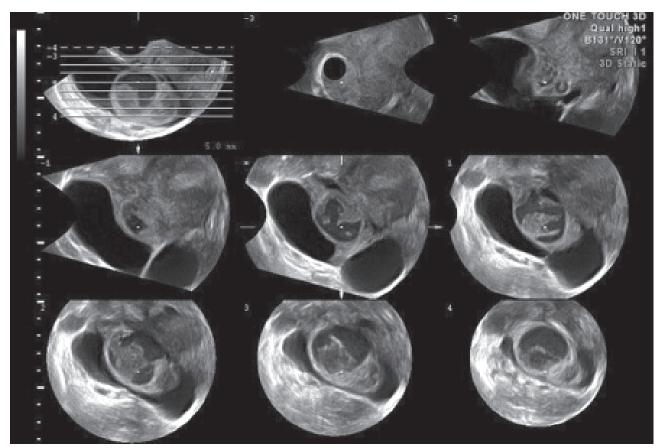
A 3D Tomographic ultrasound imaging of the same patient as in Figures 56.43A and B. Sequential sections show a distinct hydrosalpinx enveloping an ovary, one edge of which shows echogenic debris, confirming acute salpingo-oophoritis
